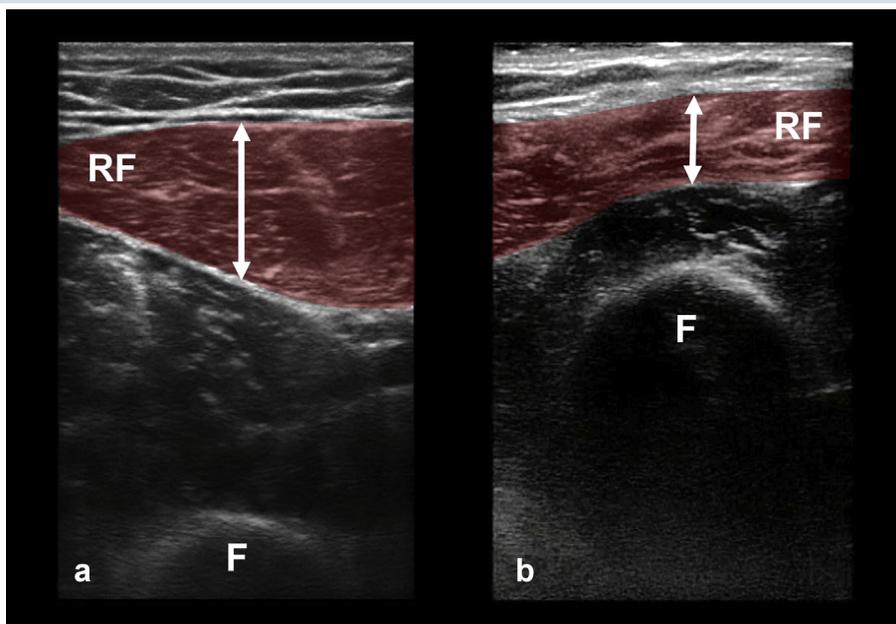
Ultrasound (US) assessment of rectus femoris (RF) muscle sarcopenia. A two-dimensional US image using a probe placed in transverse orientation at the level of the mid-anterior thigh. The RF muscle is coloured in red. The caliper measures the width of the muscle at the anterior/posterior plane of the middle of the femur (F). (a) Normal muscle mass and (b) sarcopenia.
